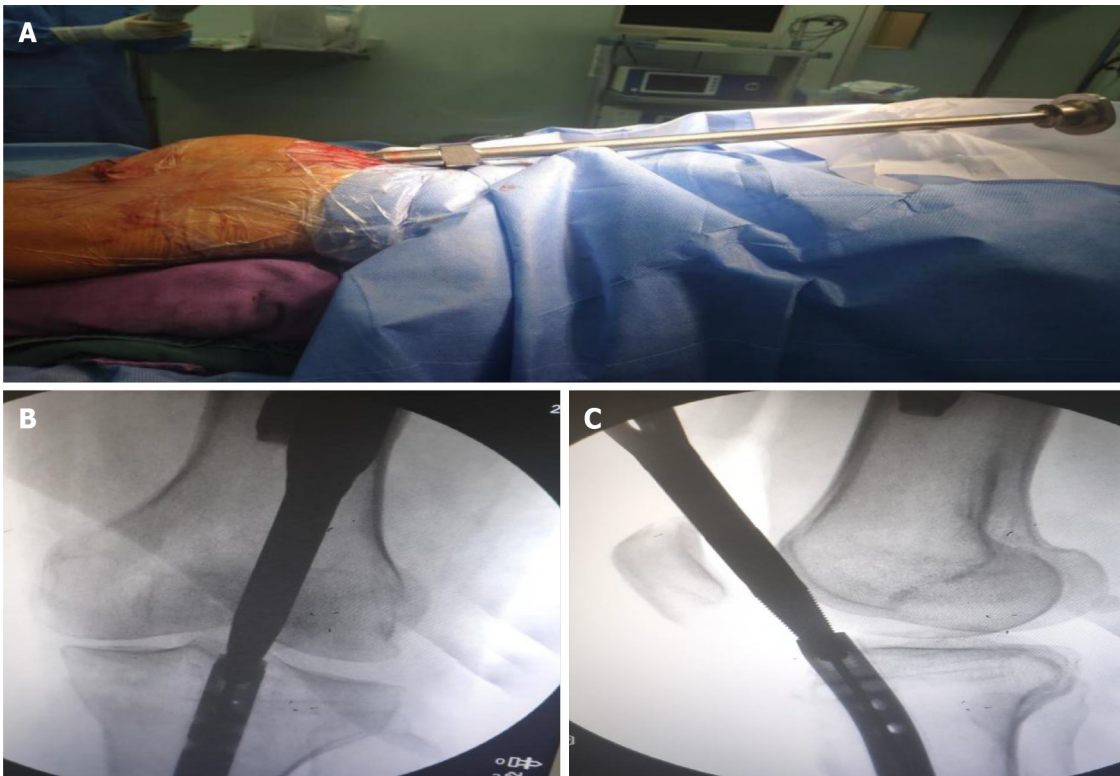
A jig was screwed into the tail of the nail. A: A hollow jig was rotated along the guide needle and screwed into the tail of the nail; B: Anteroposterior X-ray view showing that the clamp was screwed into the end of the intramedullary nail and tightened; C: Lateral X-ray view showing that the clamp was screwed into the end of the intramedullary nail and tightened.
